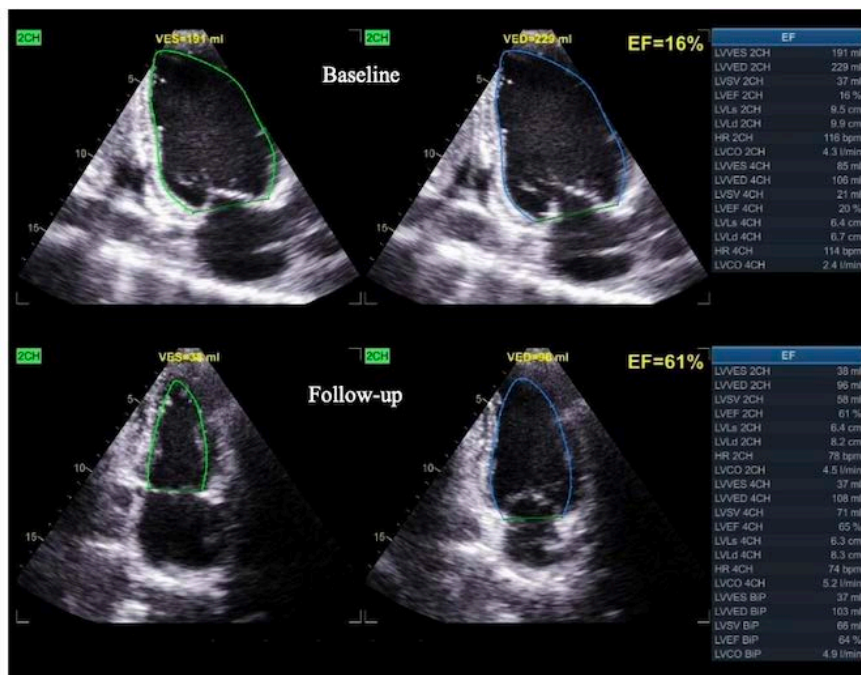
Baseline and follow-up echocardiography during 12 months of therapy showed significantly increased LVEF 16% to 61% (Simpson) and reduced LA and LV chambers size
